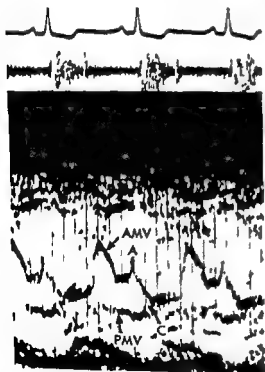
Mitral valve echocardiogram of a patient with severe paraprosthetic aortic regurgitation. The prolonged AC interval is evident. AMV = Anterior mitral leaflet. PMV = posterior mitral leaflet.
